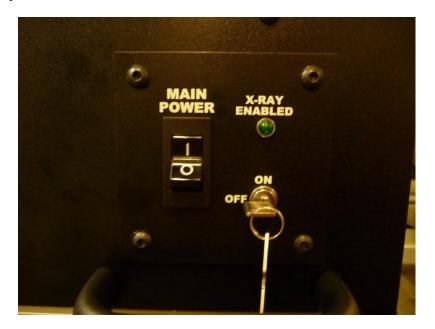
TruView X-Ray Enable Keyswitch
